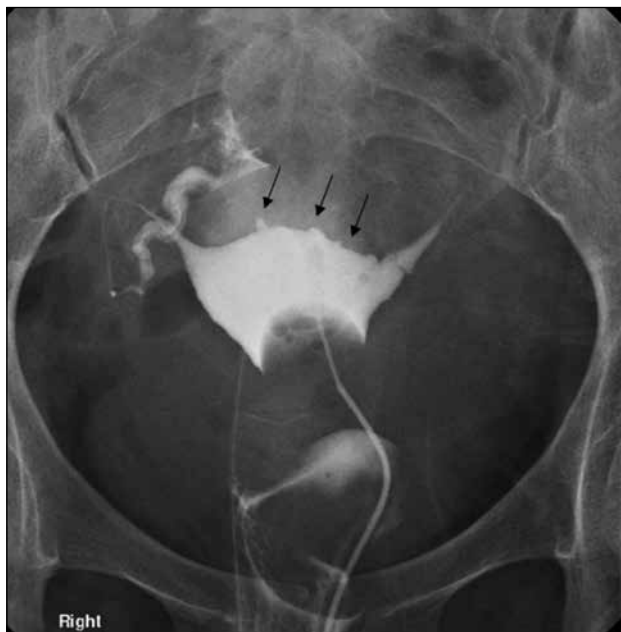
A 32-year-old woman with adenomyoma. Known fundal adenomyoma was found on prior transvaginal ultrasound. Hysterosalpingography demonstrates irregular uterine cavity contour with small outpouchings at fundal aspects (arrows), in keeping with deep extension of endometrial glandular tissues within the myometrium.
